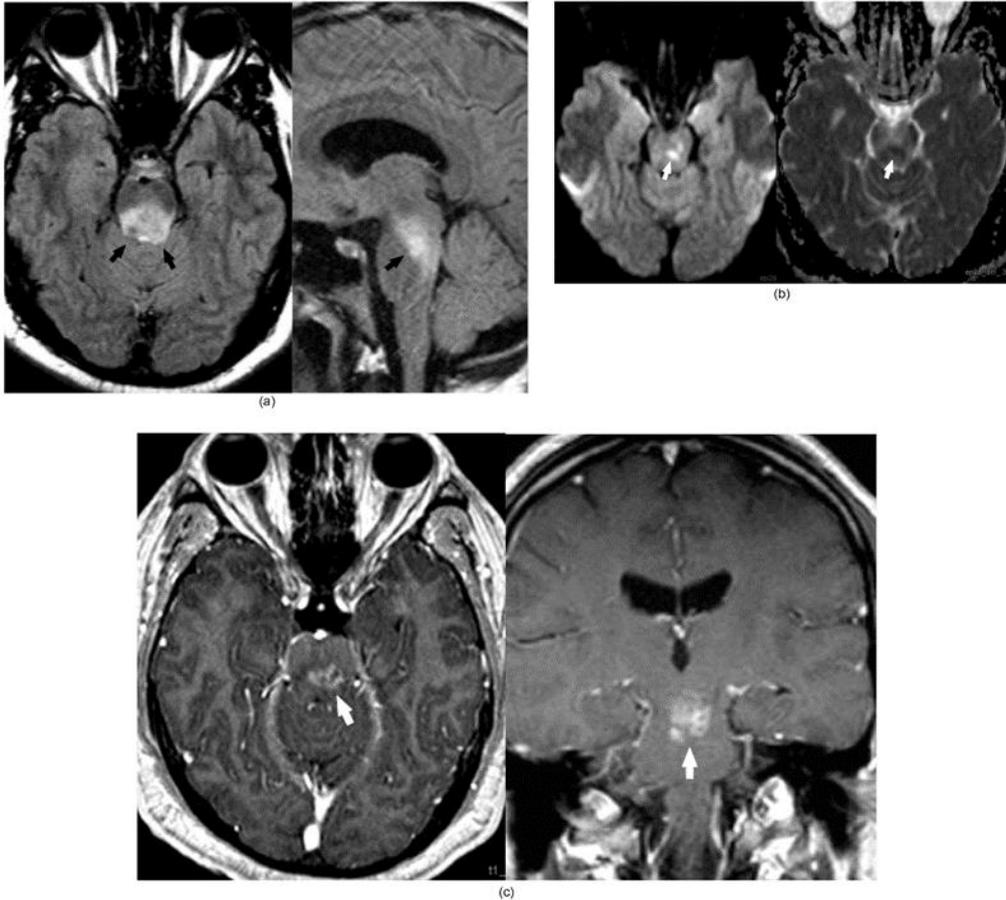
(a-c). Behçet disease. (a) Axial and sagittal FLAIR imaging (left and right respectively) demonstrates strikingly geographic abnormal hyperintense signal intensity in the midbrain and pontine tegmentum with little mass effect. (b) Areas of diffusion restriction characterized by T2 diffusion hyperintense and ADC hypointense signal (left and right respectively, white arrows) in the left paramedial caudal midbrain reflective of acute or early subacute infarction. (c) Axial and coronal post gadolinium T1-weighted images (left and right respectively) demonstrate peripheral curvilinear and punctate nodular enhancement. Abbreviations: FLAIR, fluid attenuation inversion recovery; ADC, apparent diffusion coefficient. Courtesy of Adam Davis, MD.
